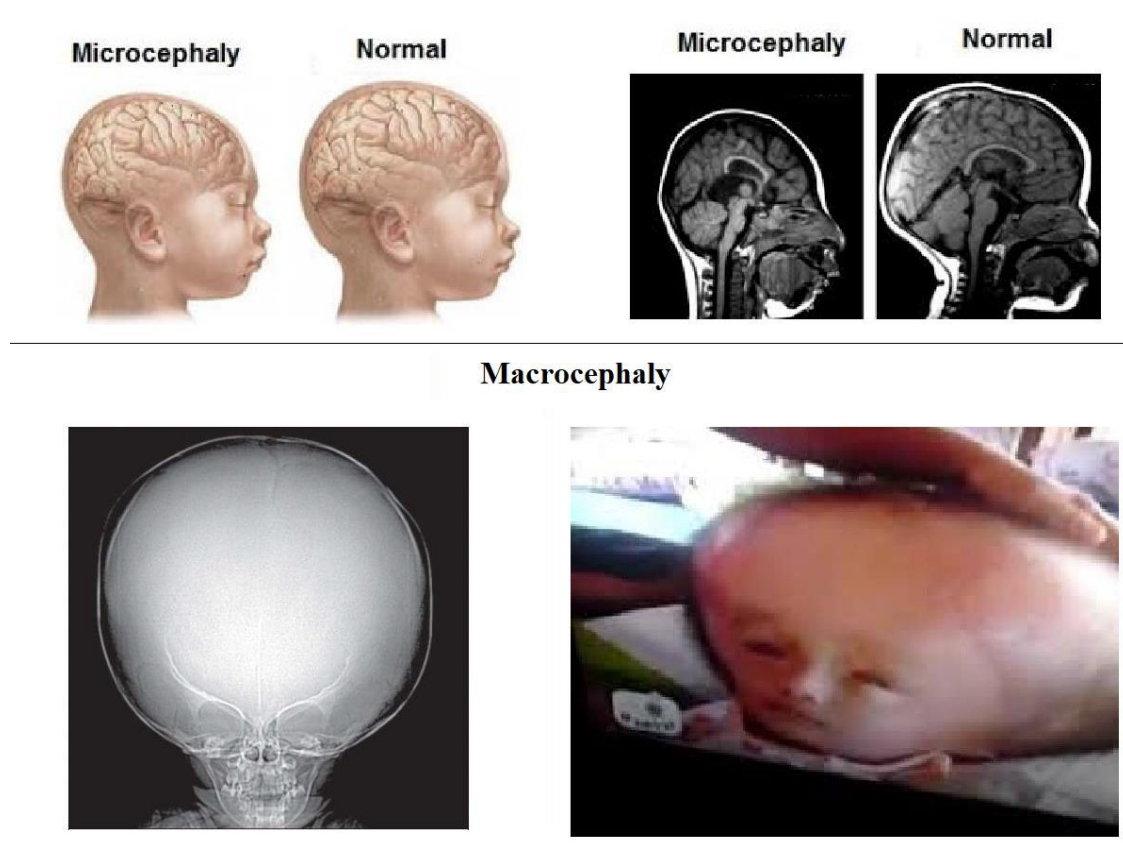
Two subject with and Macrocephaly condition and their related MRI images
